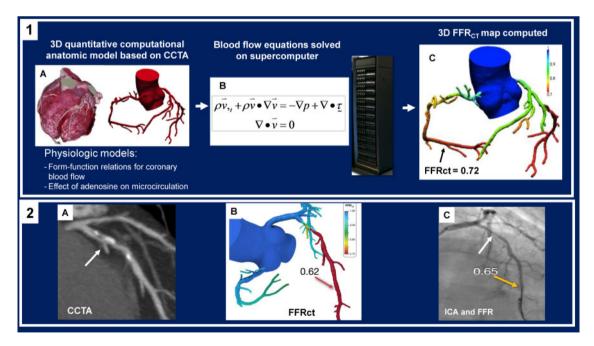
Panel 1: FFR_{CT} analysis provides noninvasively derived FFR information calculated from a standard CCTA (A) using machine-learning algorithms (B) to create a 3D model of the coronary arteries (C). Once this patient-specific model is completed, the process applies physiologic principles and computational fluid dynamics to compute the blood flow and FFR derived from CCTA (FFR_{CT}) values at every point in the model. The completed analysis is a color-coded, digital 3D model of the heart and coronary arteries reflecting the impact that a stenosis has on blood flow. Panel 2: CCTA showing a stenosis (arrow) of the proximal LAD (A). FFR_{CT} demonstrates ischemia in the LAD (computed value of 0.62) (B). Invasive coronary angiography (ICA) confirms the proximal stenosis (white arrow) while invasive FFR confirms ischemia (yellow arrow) in the LAD (0.65) (C). CCTA, coronary computed tomography angiography; FFR, fractional flow reserve; LAD, left anterior descending
